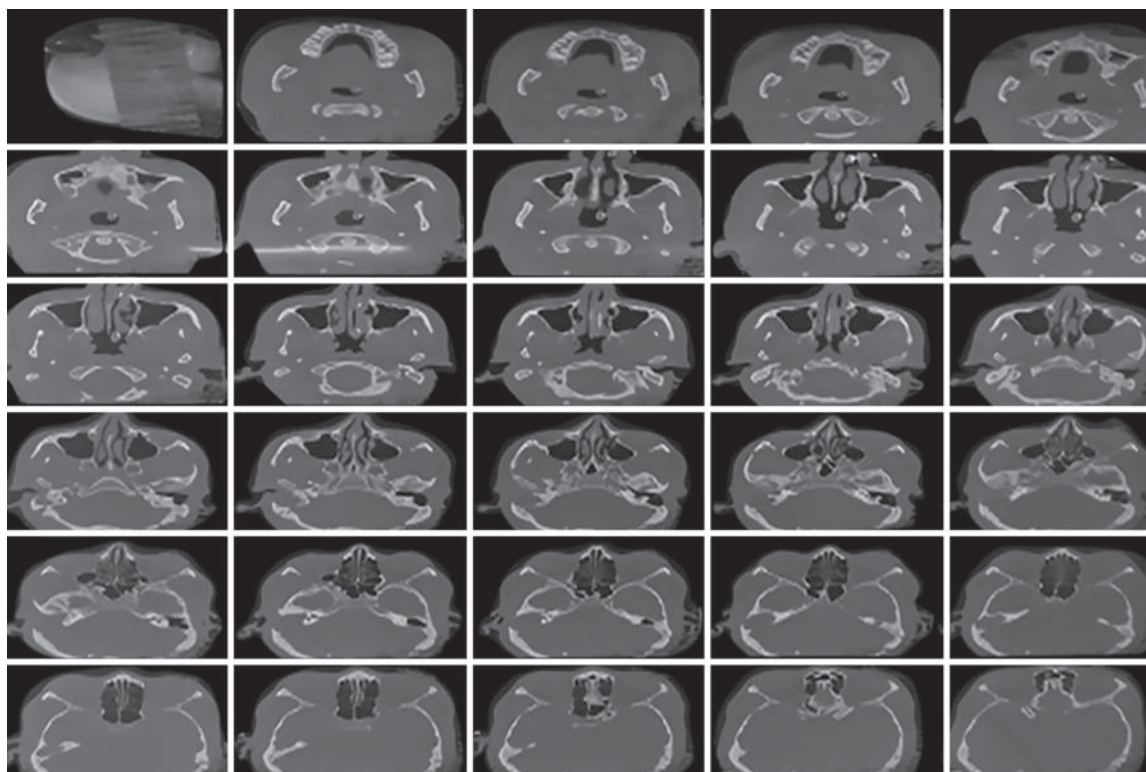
High-resolution computed tomography of temporal bone depicting destruction of right sinodural plate and right tegmen tympani (November 6, 2016)
